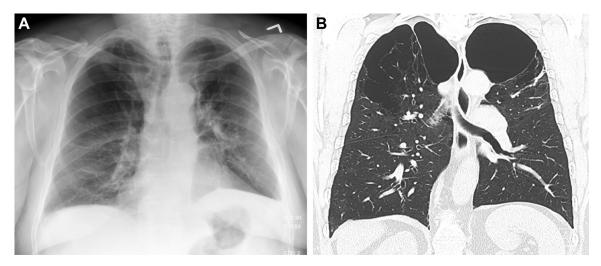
A, Posterior-anterior chest radiograph in a 63-y-old man with heavy smoking history showing relative hyperlucency in the upper zones bilaterally. B, Coronal CT image on lung windows in the same patient showing severe centrilobar and paraseptal emphysema with bullous changes, with characteristic upper lobe predominance typical for smoking-related emphysema.
